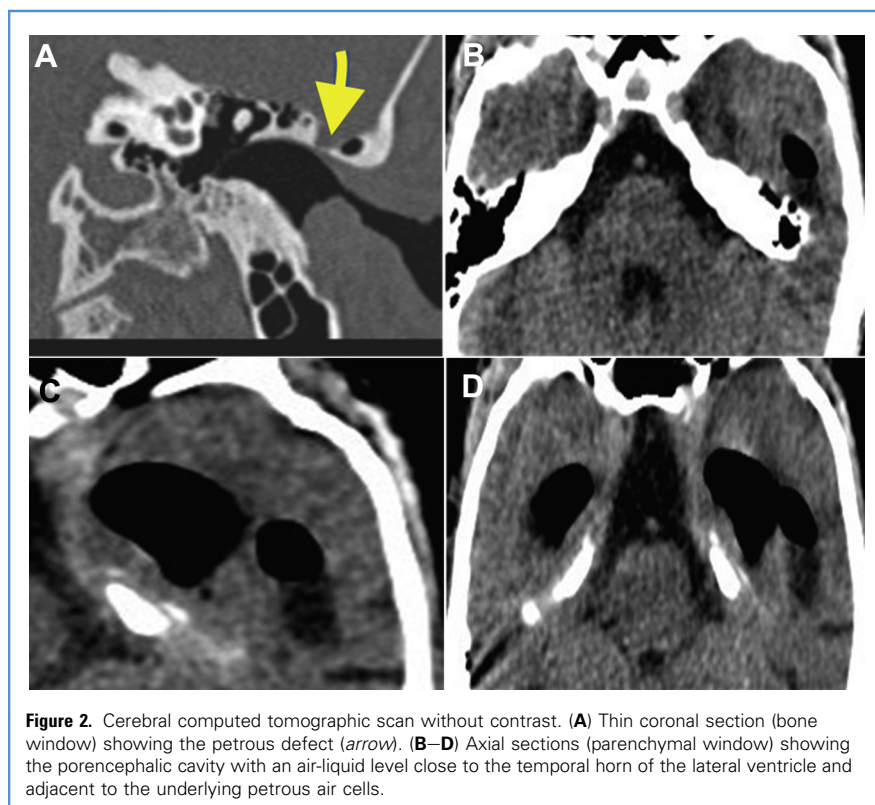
Cerebral computed tomographic scan without contrast. (A) Thin coronal section (bone window) showing the petrous defect (arrow). (B–D) Axial sections (parenchymal window) showing the porencephalic cavity with an air-liquid level close to the temporal horn of the lateral ventricle and adjacent to the underlying petrous air cells.
